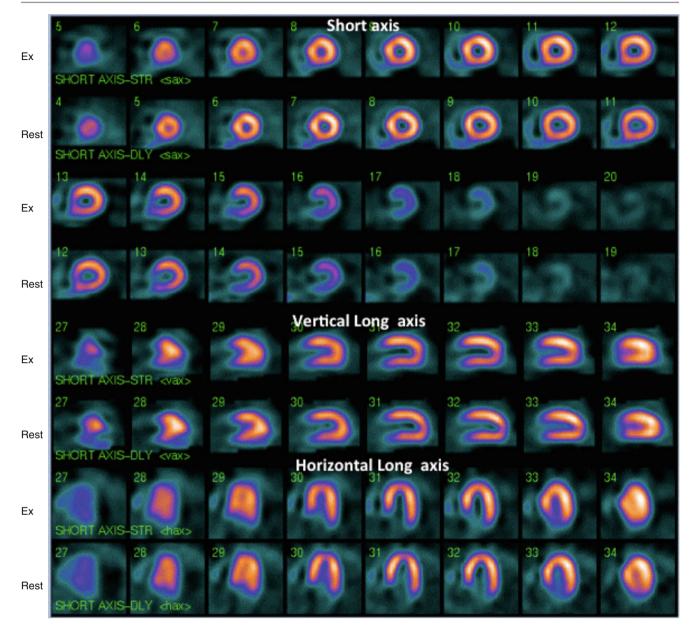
Exercise (*Ex*) and rest ^{99m}Tc-tetrofosmin SPECT images of a 51-year-old man with end-stage renal disease and hypertension, who underwent Ex-rest myocardial perfusion imaging as a part of cardiac evaluation prior to renal transplant. He had no symptoms of CAD. He exercised for 12 min using Bruce protocol and had no chest pain or ST segment depression. He attained age-predicted maximum heart rate. Ex
